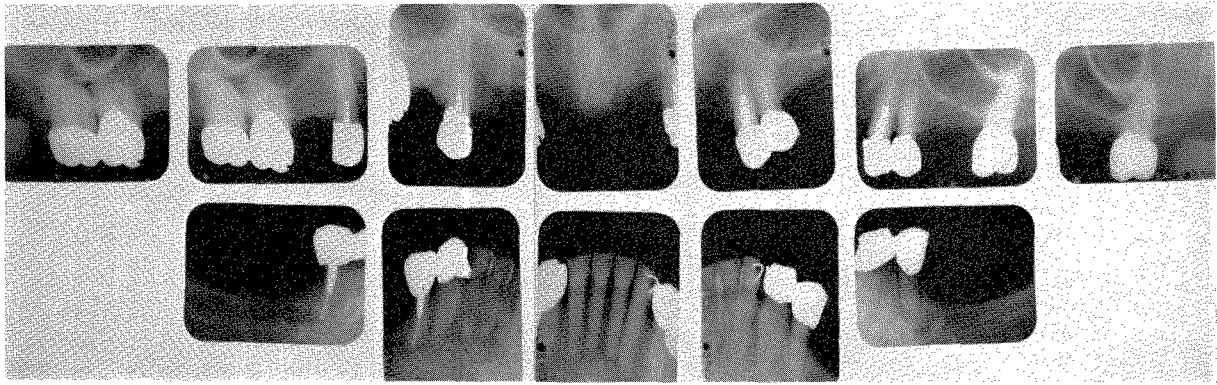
Roentgenograms taken in December, 1962. This was seventeen and one-half years after the original rehabilitation. The lower teeth were retained only because of the rigid splinting.
